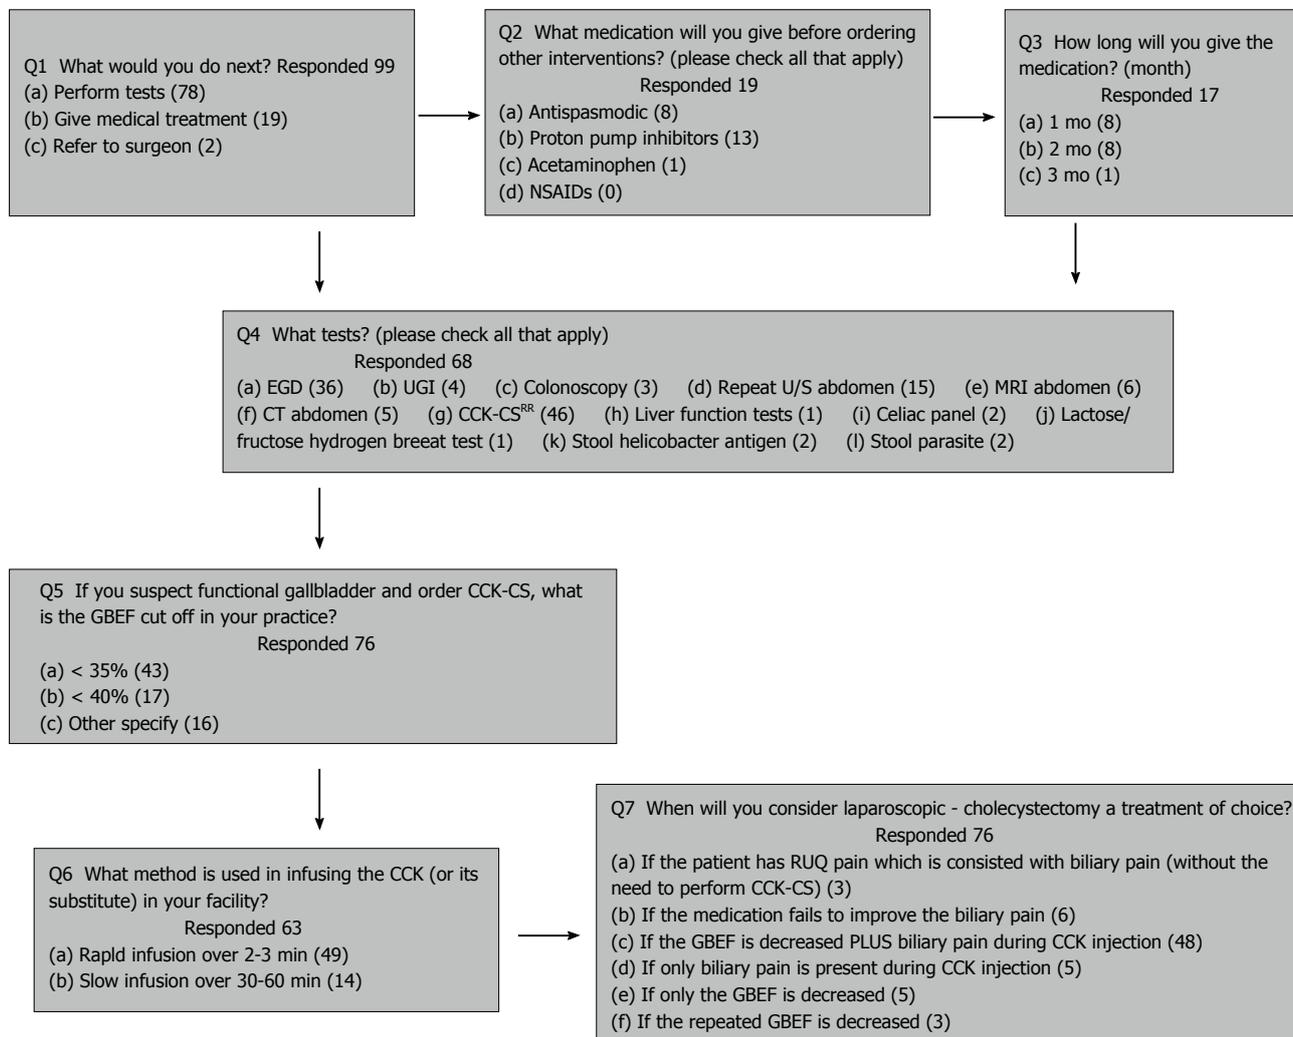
Questionnaire for pediatric gastroenterologists to assess a case with chronic right upper quadrant pain. EGD: Esophagogastroduodenoscopy; UGI: Upper gastrointestinal; U/S: Ultrasonography; MRI: Magnetic resonance imaging; CCK-CS: Cholecystokininscintigraphy scan; GBEF: Gallbladder rejection fraction; RUQ: Right upper quadrant; NSAIDs: Nonsteroidal anti-inflammatory drugs.
